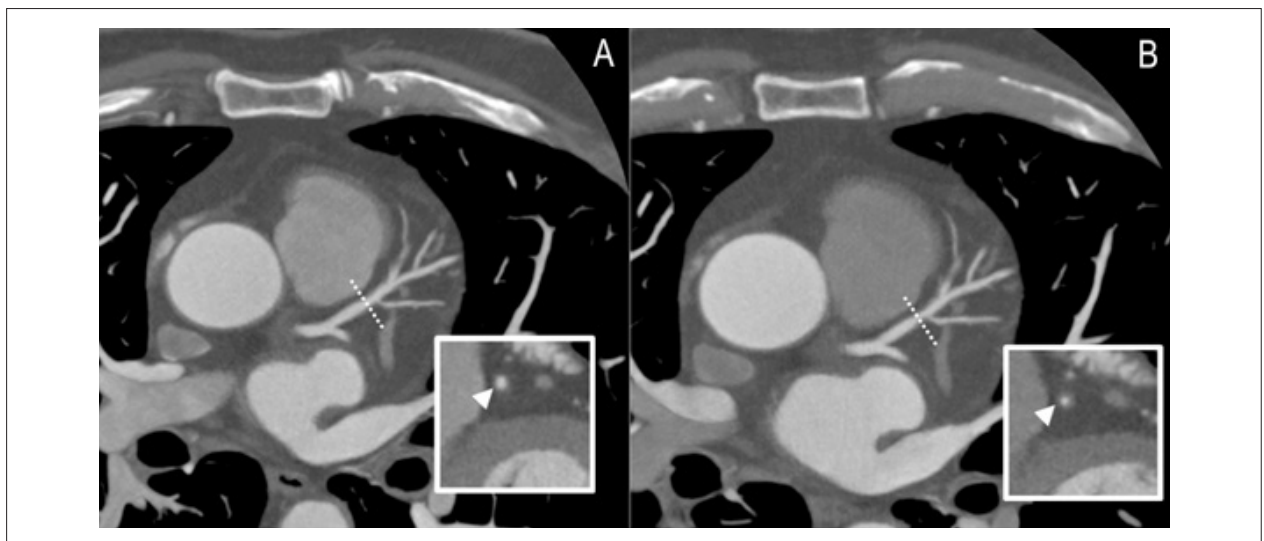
Coronary artery disease (CAD) progression on coronary computed tomography angiography (CCTA) in a 58-year-old male presenting a very mild CAD in the proximal left anterior descending coronary artery at baseline (A). Evident disease progression is seen at 13 months at the same site, with moderate luminal stenosis (B) best appreciated in the vessel's transverse plane (arrowhead).
